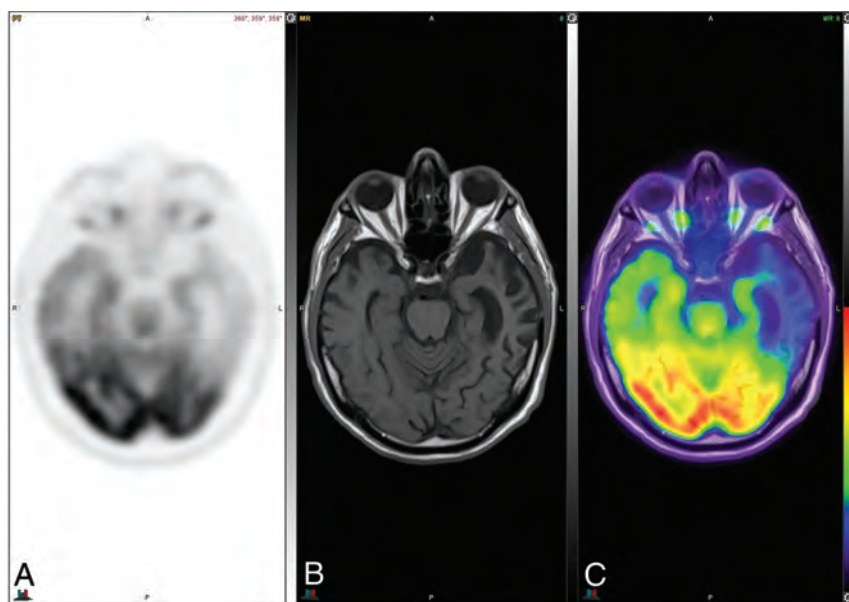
[^{18}F] FDG-PET (A), axial T1 (B), and PET MR imaging (C) views demonstrate an abnormal FDG distribution pattern with markedly decreased tracer uptake in the temporal lobes, particularly in the left temporal pole. There is corresponding advanced cortical atrophy with a “knife-blade” appearance in the left anterior temporal lobe on the axial T1 sequence.
